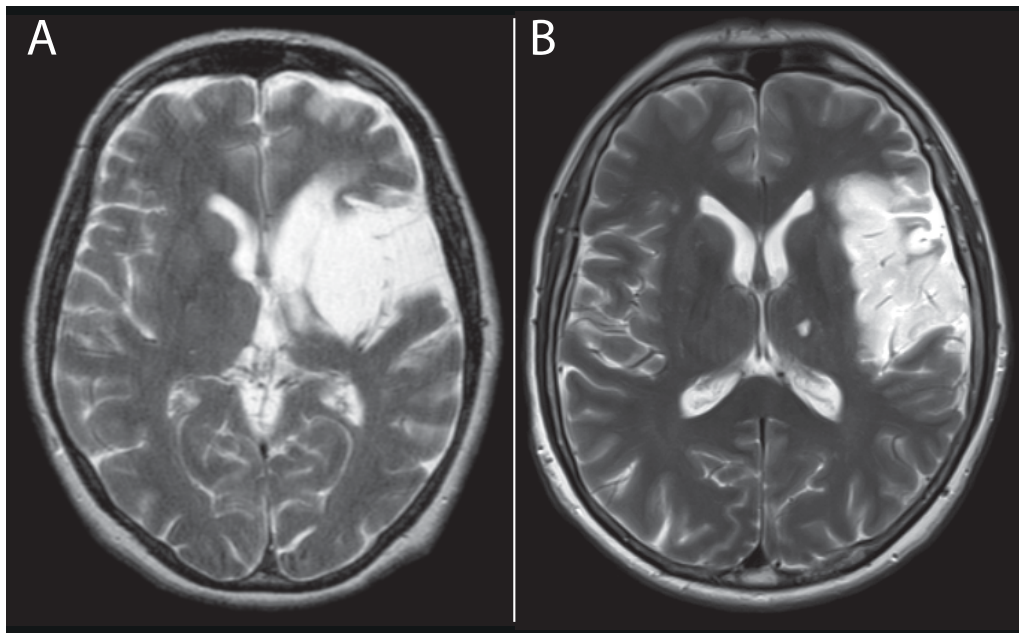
T₂-weighted MRI scans (axial view) of patients PR (A) and AS (B). Both scans show left middle cerebral artery infarctions, with only patient PR's lesion including the left basal ganglia.
